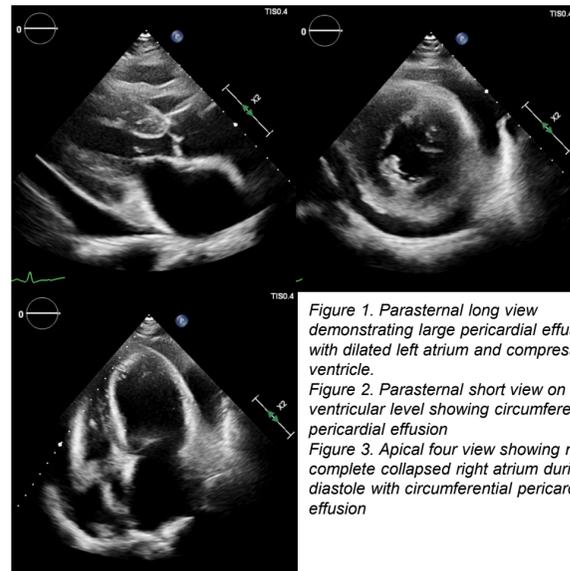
Parasternal long view demonstrating large pericardial effusion with dilated left atrium and compressed left ventricle.
